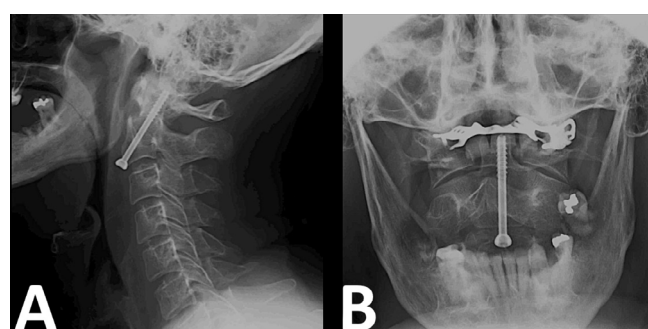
Postoperative (A) lateral and (B) open mouth radiographs demonstrating excellent reduction and fixation of the Type II odontoid fracture with a single titanium cannulated lag screw.
